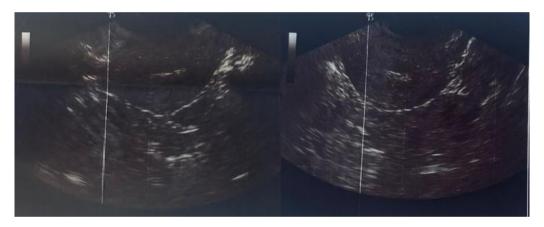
Ultrasound showed a thin vacuity line and no IUD in the uterus or in the thickness of the myometrium.
